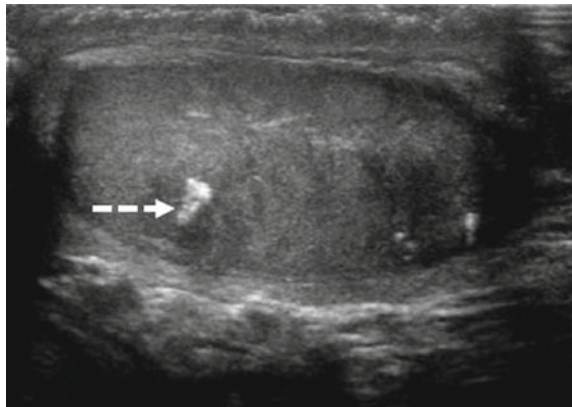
Postpubertal teratoma on doppler US, as a complex heterogeneous mass with calcifications and cystic lesions (arrowhead)³⁸
